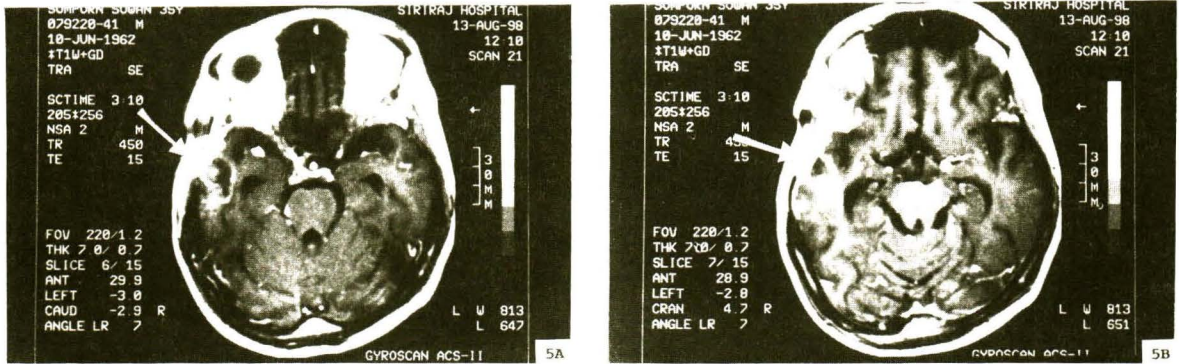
(A, B) Axial postcontrast T1 - weighted scans showed subtle meningeal enhancement over the right temporal lobe with an ill-defined contrast enhancing area that represented cerebritis (compare to CT scan in Fig. 3).
